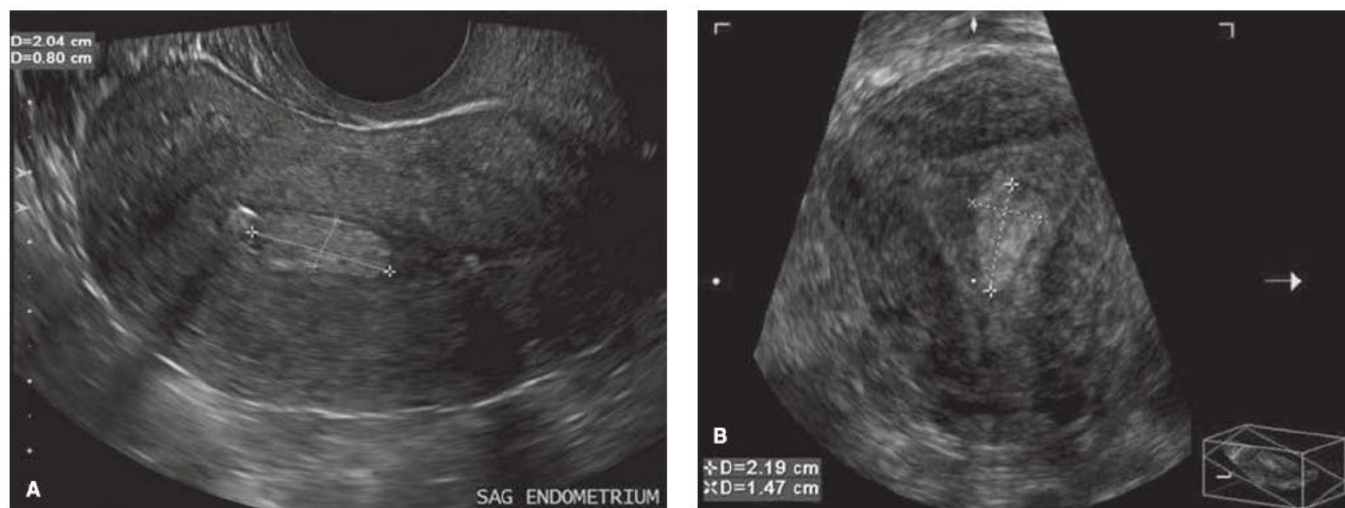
A. Transvaginal sonogram displays endometrial polyp measured by calipers. B. Three-dimensional image in the coronal plane of a polyp (calipers).
